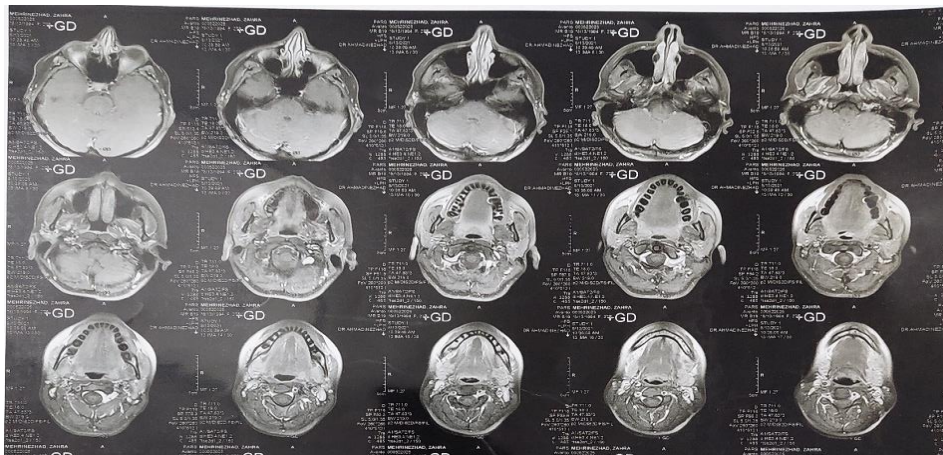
MRI imaging which was suggestive for metastatic lymph nodes or infectious lymphadenitis
